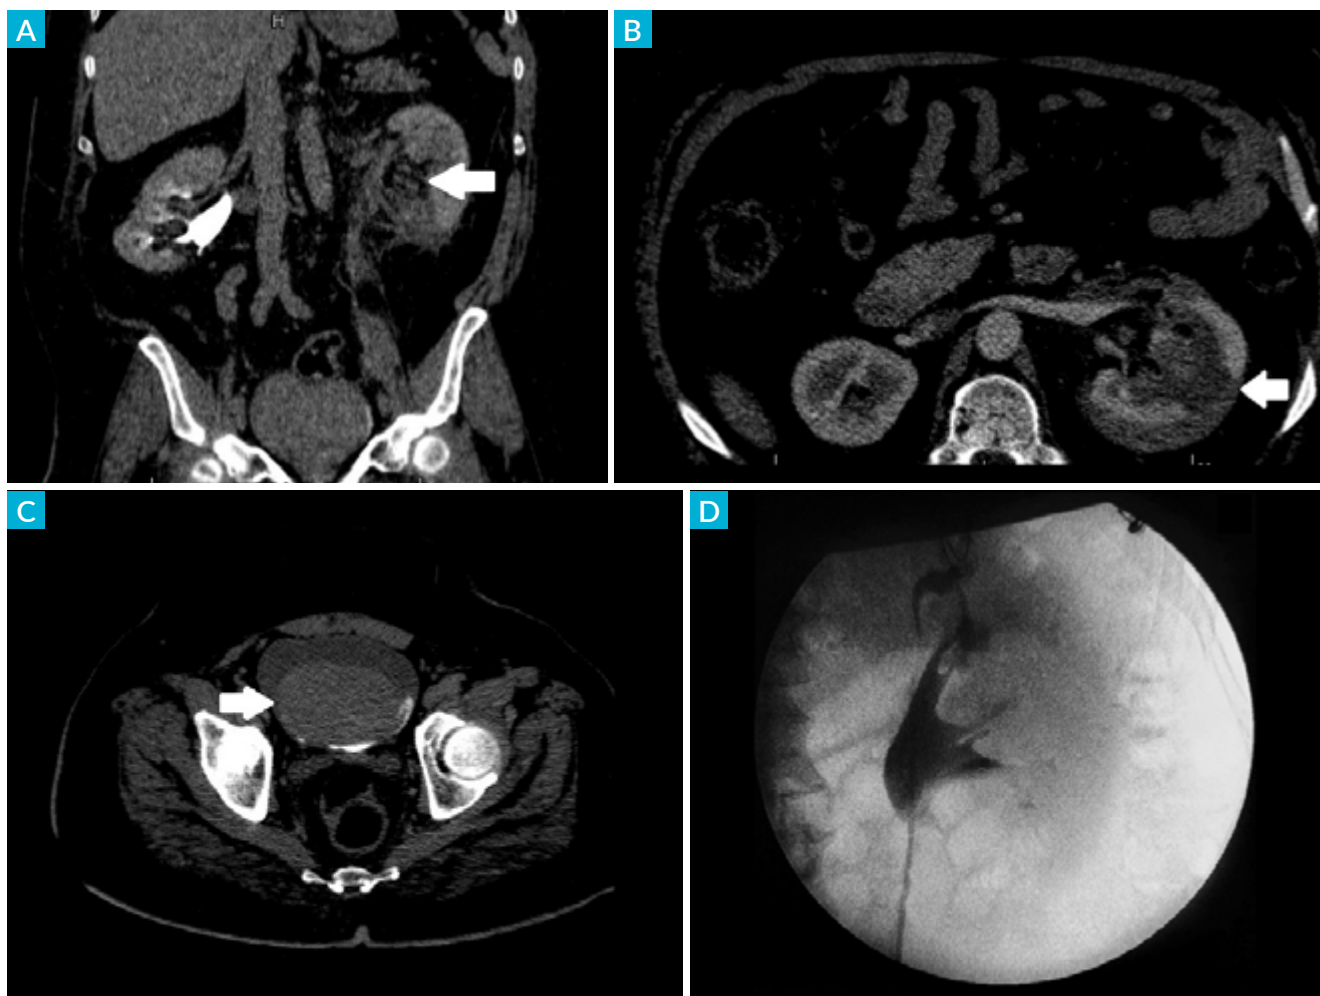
(A) Coronal contrast-enhanced in the excretory/delayed phase showing absence of contrast concentration and excretion in the left kidney (white arrow). (B) Axial venous-phase CT demonstrating an enlarged left kidney, without contrast enhancement, related to sub-capsular hematoma and contusional renal oedema (white arrow). (C) Axial CT (delayed-phase) showing spontaneously hyperdense content within the urinary bladder, compatible with acute hematic content (white arrow). (D) Coronal acquisition during retrograde pyelography for double-J stent placement, without extravasation of intravenous contrast, excluding renal pelvic rupture.
